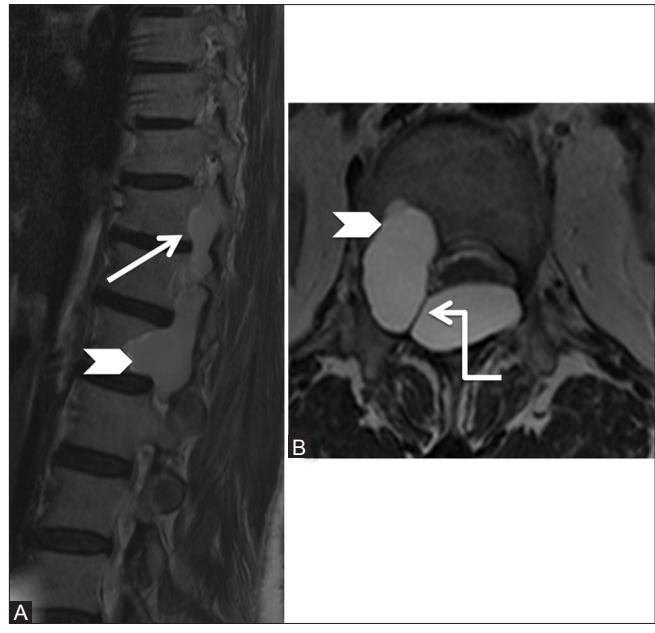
(A and B): Benign lesions: Arachnoid cyst: Parasagittal (A) and axial (B) T2-weighted images showing arachnoid cyst (arrow) extending from the posterior epidural space into the intervertebral foramina and causing scalloping of posterior vertebral body on the right side (arrowhead). Note the meningovertebral ligament traversing the lesion (elbow arrow)
